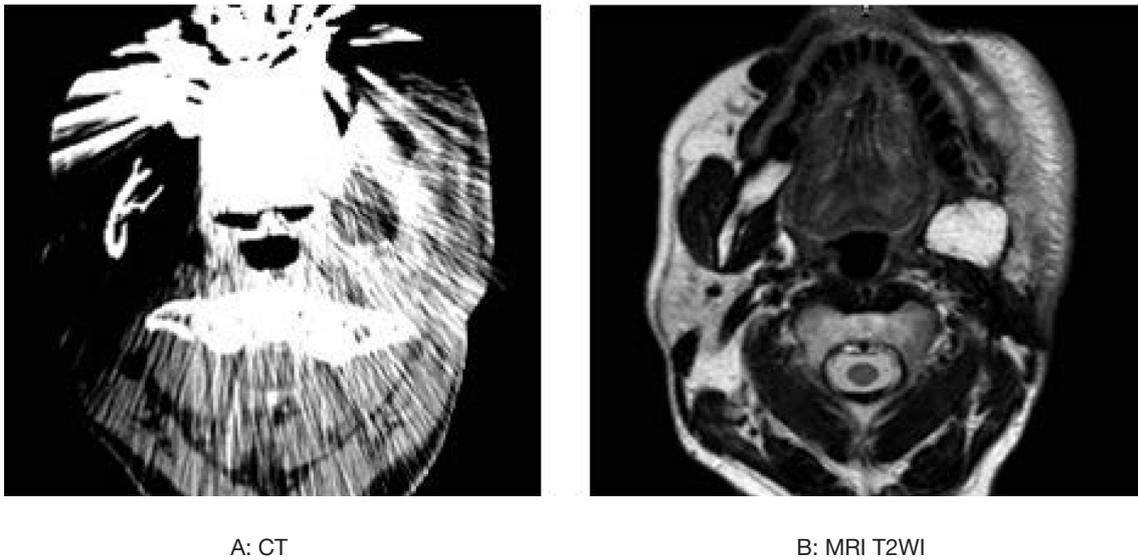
Metal artifact in CT.
